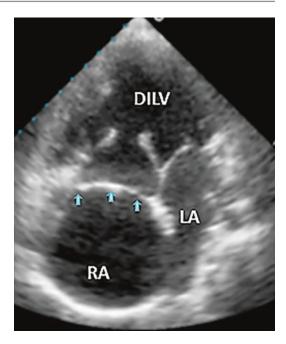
2D echocardiography, apical four chamber view; post Fontan; arrow point to the Patch above right AV valve
